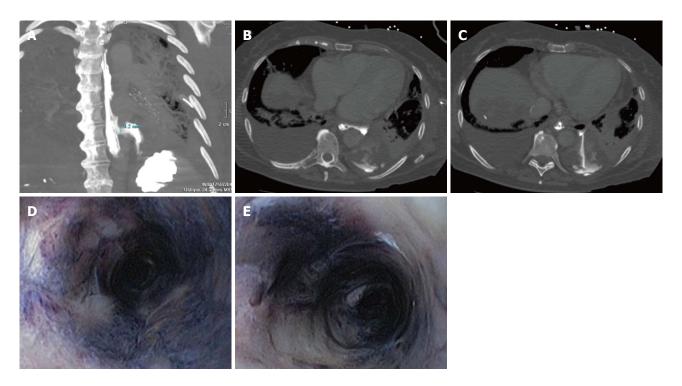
Computed tomography-thorax scan with contrast given via the nasogastric feeding tube. A: A coronal coupe where the esophagus is seen to the left of the vertebral column and the perforation lights up two thirds of the esophagus with leakage of contrast into the pleural space; B and C: Transversal coupes of the thorax with contrast leakage via the esophagus into the pleural space; D and E: A circumferentially black-appearing esophagus at endoscopy.
